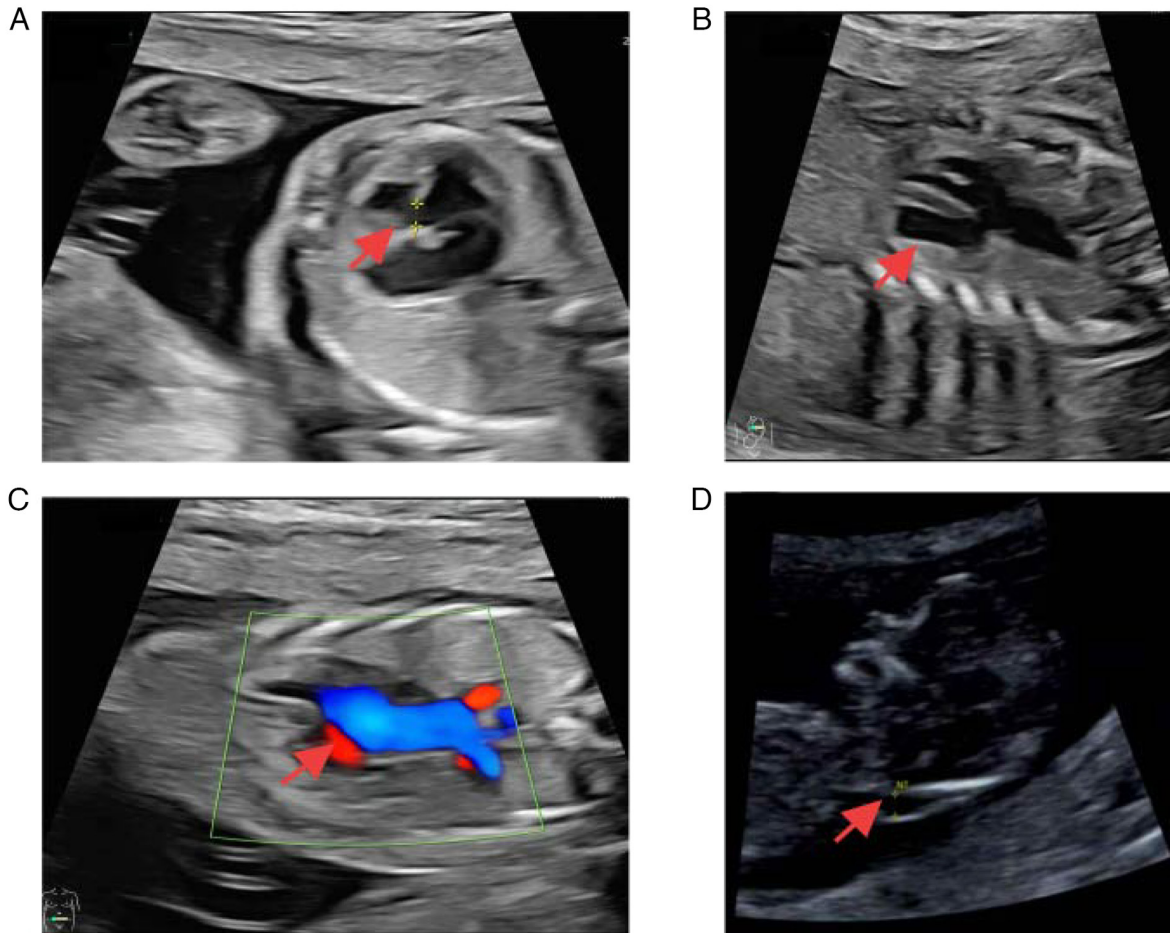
Abnormal ultrasound results of the fetuses with 11q syndrome. (A) Case 2 four-chamber view ultrasound result indicated a continuous interruption of the ventricular septum. (B) Case 2 two-dimensional ultrasound result indicated a single arterial trunk. (C) Case 2 three-vessel cross-sectional ultrasound result indicated the presence of a large artery. (D) Case 4 ultrasound results indicated thickening of the NT. NT, nuchal translucency.
